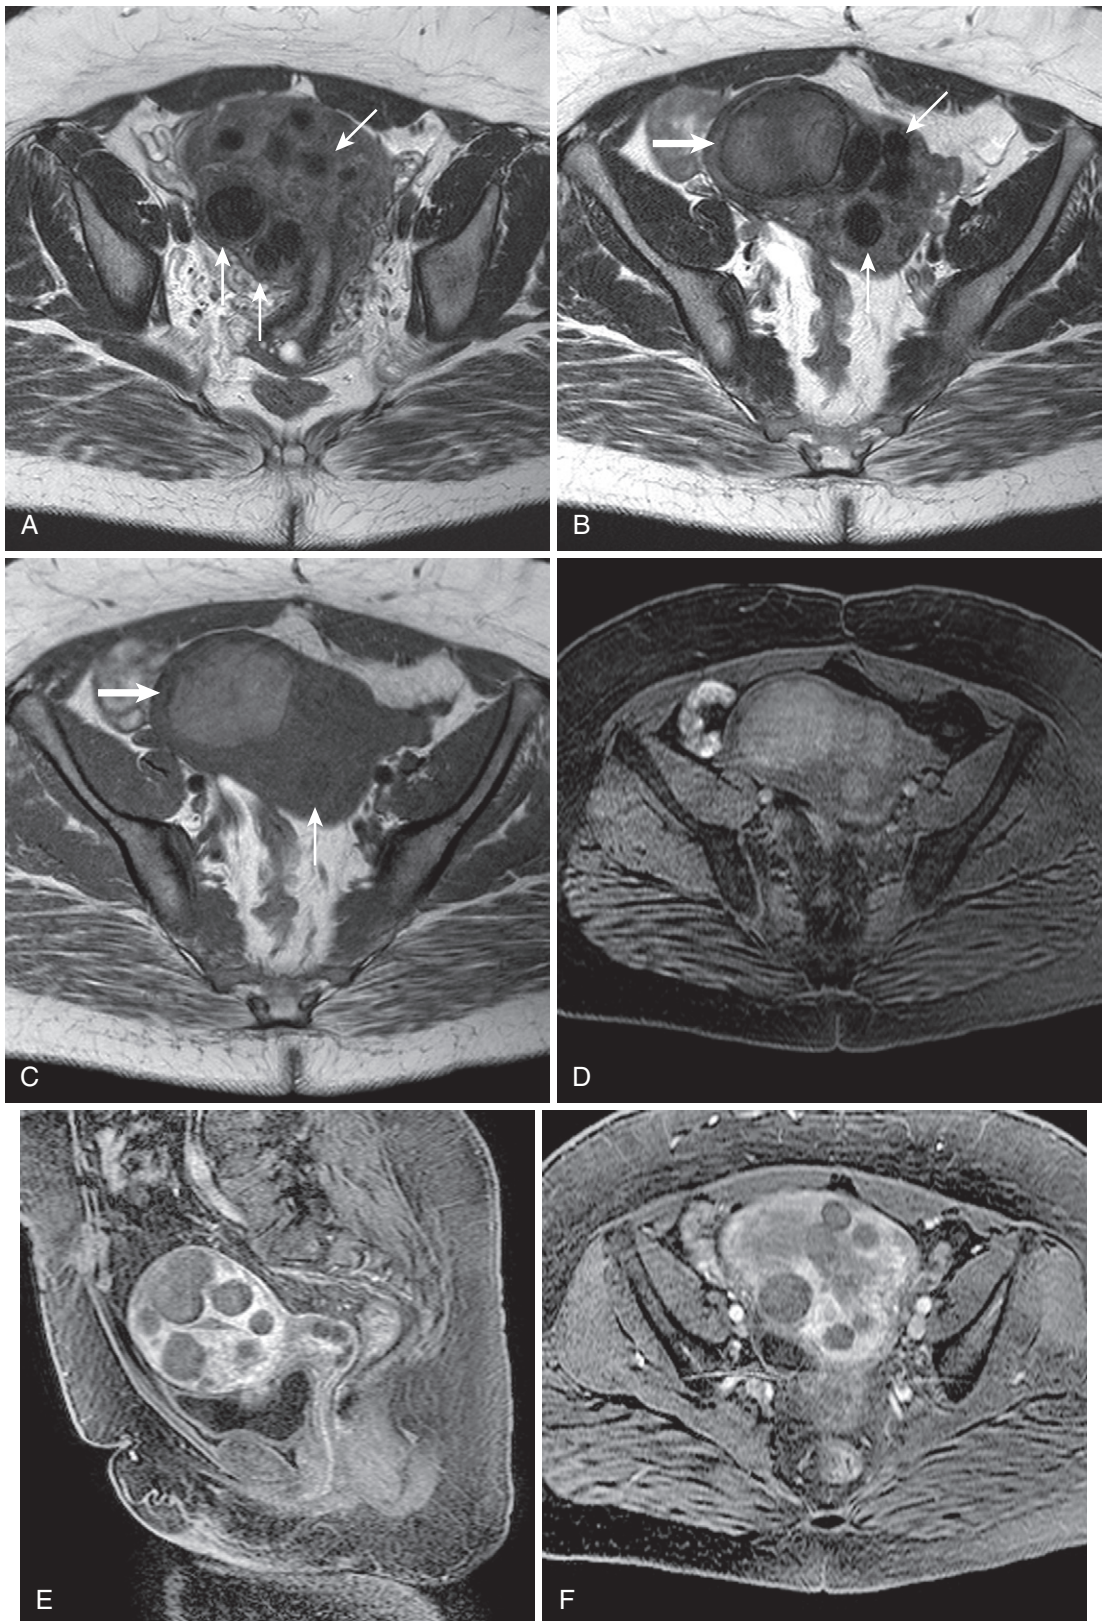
Hypovascular fibroids. Axial T2-weighted (A and B) and T1-weighted (C) images reveal multiple hypointense intramural fibroids (*thin arrows* in A-C) and a large hyperintense (hemorrhagic) fibroid arising from the right lateral myometrium (*thick arrow* in B and C). Comparing the precontrast (D) with the enhanced images (E and F) indicates a relative lack of enhancement.
